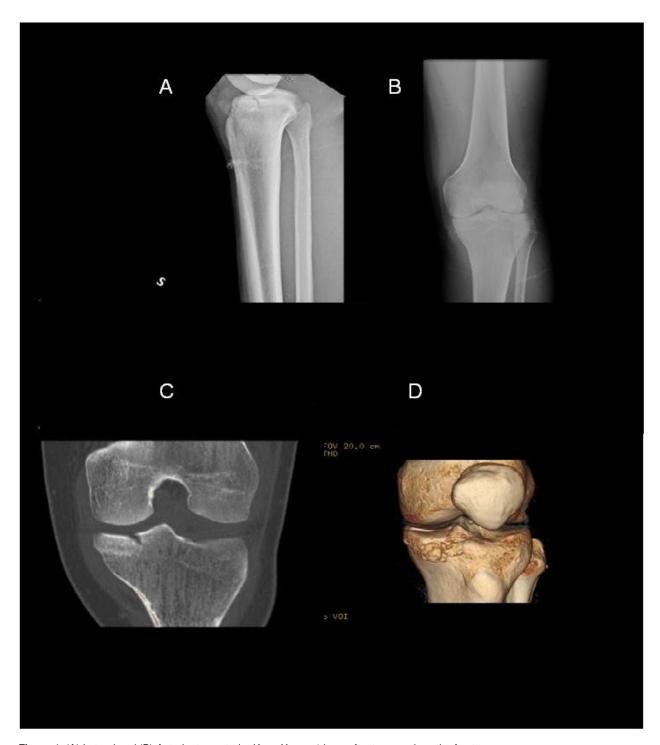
(A) Lateral and (B) Anterior to posterior Knee X-rays 1 hour after trauma show the fracture. (C, D) Standard and 3D-CT Knee scan images
